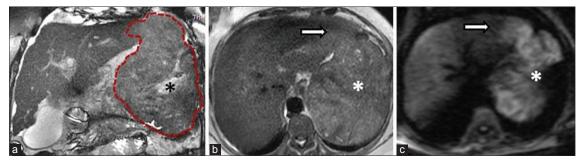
Non-enhanced magnetic resonance imaging images of the tumor (a) coronal balanced steady state free precession sequence depicting the extent of the heterogeneous soft tissue mass in the left subdiaphragmatic location, abutting the left lobe of liver (red dotted outlines of tumor margins)with a central hyperintense scar(*) (b) T2-weighted axial sequence of the upper abdomen demonstrating small area in left lobe of liver, segment II (bold arrow) showing heterogeneity of signal in contiguity with the left subdiaphragmatic mass lesion (*) (c) diffusion weighted sequence (b value=1000) showing restriction of the segment of liver (bold arrow) and the restricted signal of the mass lesion (*)
